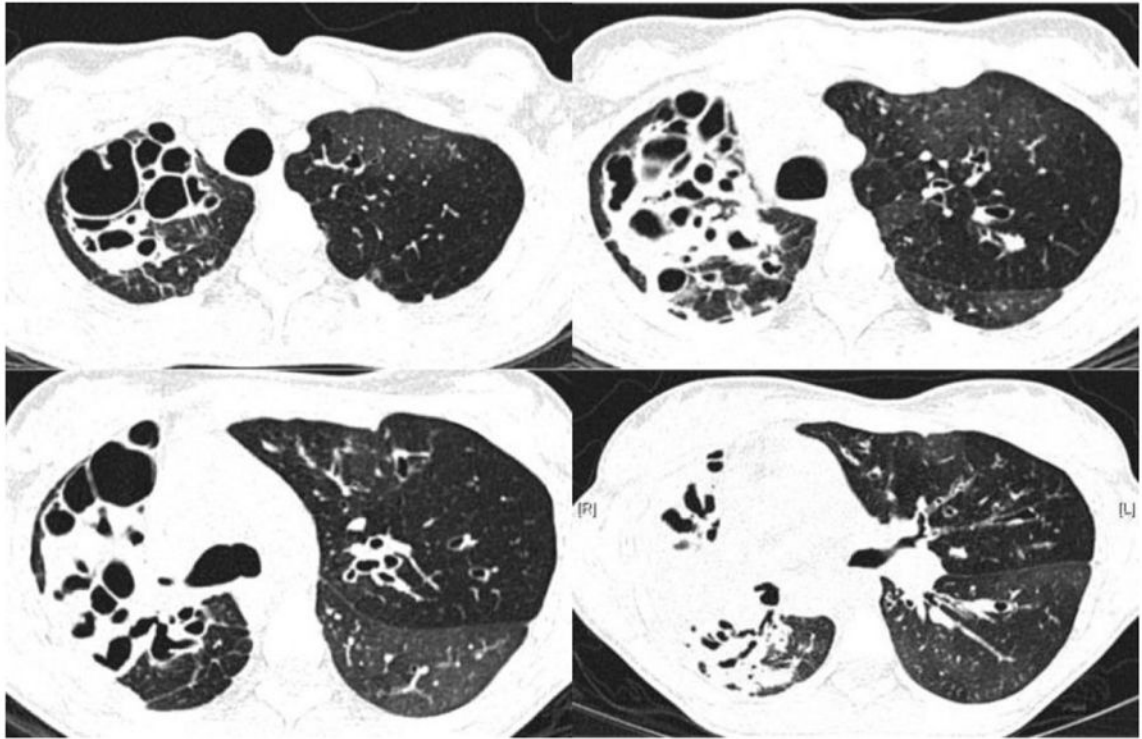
Chest CT of a 28-year-old woman with cystic fibrosis and chronic multidrug resistant *Pseudomonas aeruginosa* infection, showing extensive bronchiectasis and nearly complete destruction of the right lung. The left lung remains relatively uninvolved but demonstrates areas of mosaic attenuation representative of air trapping.
